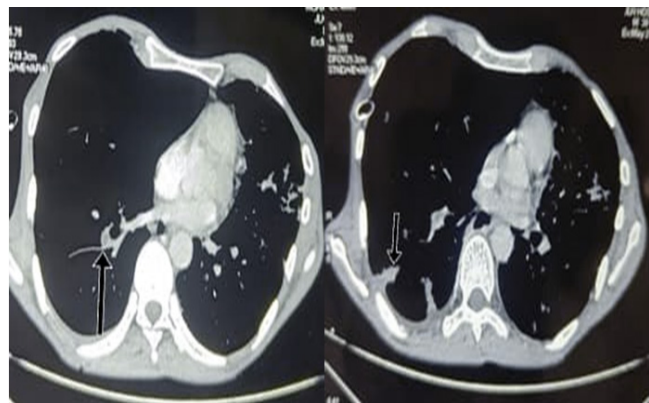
(A and B) Contrast enhanced CT Chest showing Pulmonary thromboembolism involving the segmental branch of the right lower lobe pulmonary artery (↑), and wedge-shaped pulmonary infarction in right lower lobe (↓)
